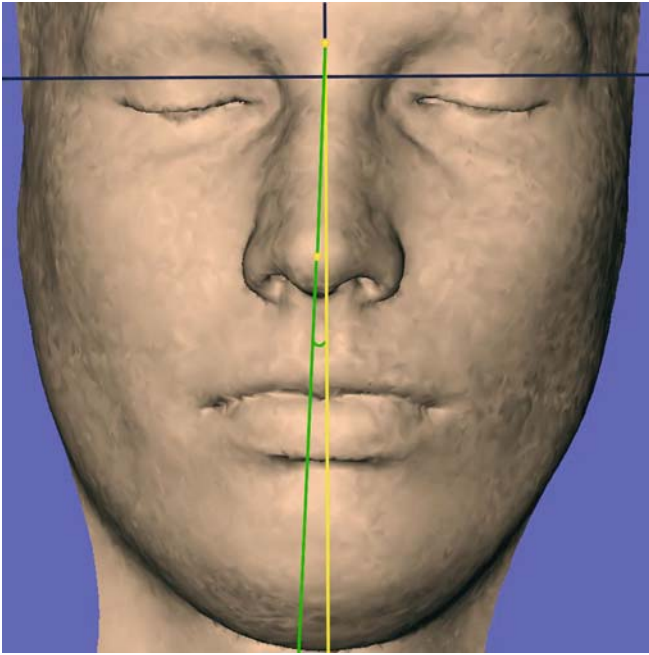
The deviation of the nasal bridge from the median plane n-prn / z-plane, is a projected angular soft tissue measurement on the vertical (y) 3-D cephalometric reference plane (3-D CT, soft tissues, patient K.C.)
